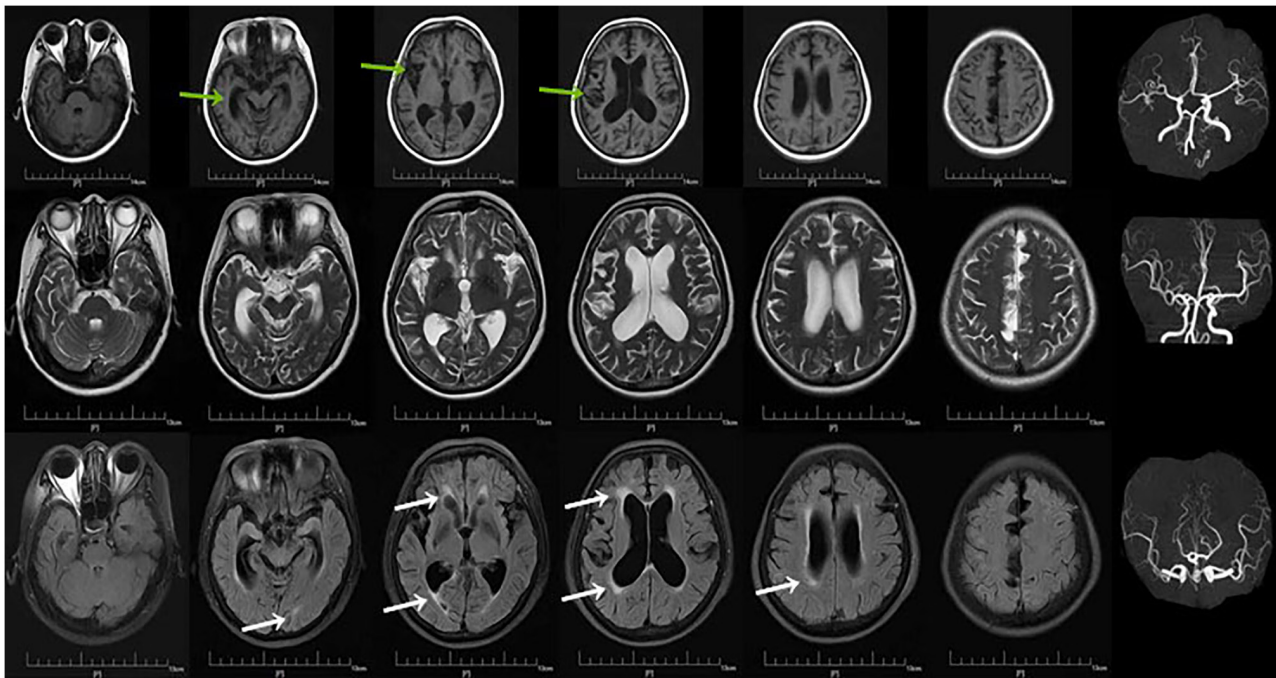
Brain magnetic resonance imaging performed in the outpatient setting in June 2025. Fluid-attenuated inversion recovery sequence demonstrated periventricular white matter hyperintensity (white arrow), while T1-weighted imaging revealed cerebral atrophy (green arrow).
